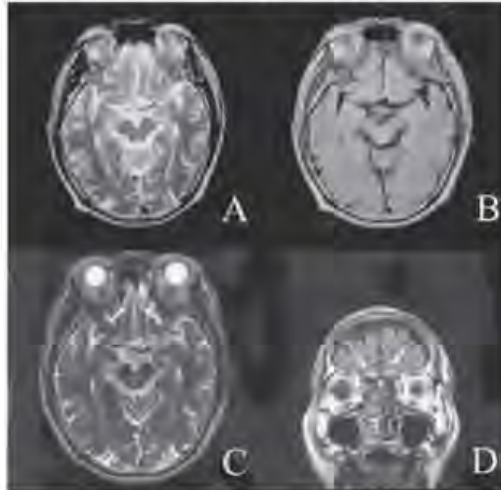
Panels A and B (1.5T MRI T2-weighted and FLAIR [slice number = 20; slice thickness = 5 mm] images, respectively) highlight unclear high-intensity signals in the orbitofrontal cortex (OFC). Panels C and D (3T MRI T2-weighted and FLAIR [slice number = 32; slice thickness = 3.5 mm] images, respectively) provide a more clear depiction of the high intensity signals (arrows) in the bilateral OFC.
